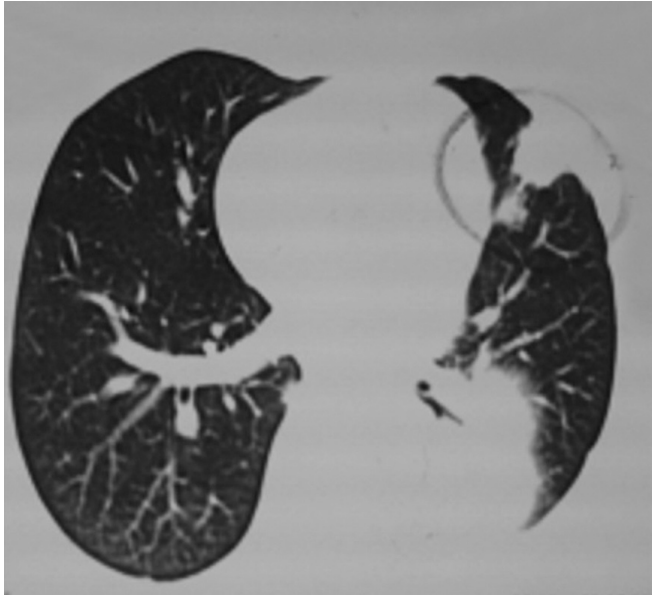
Chest CT: nodular image at left upper lobe upper portion, adjacent to the pleura.
